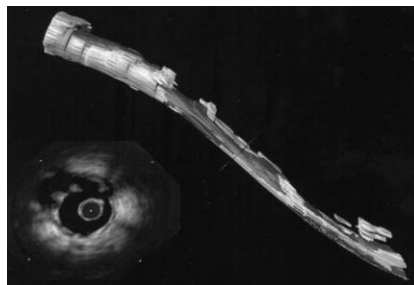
Three-dimensional visualization of coronary artery reconstructed from sequence of intravascular ultrasound images
